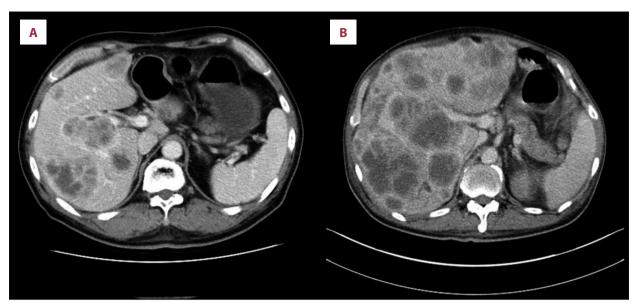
(A) Abdominal computed tomography (CT) at the time of diagnosis of meningeal carcinomatosis showed newly developed hepatic metastases. (B) Metastatic lesions in liver progressed despite systemic palliative chemotherapy, being considered as a main cause of deterioration of the patient.
